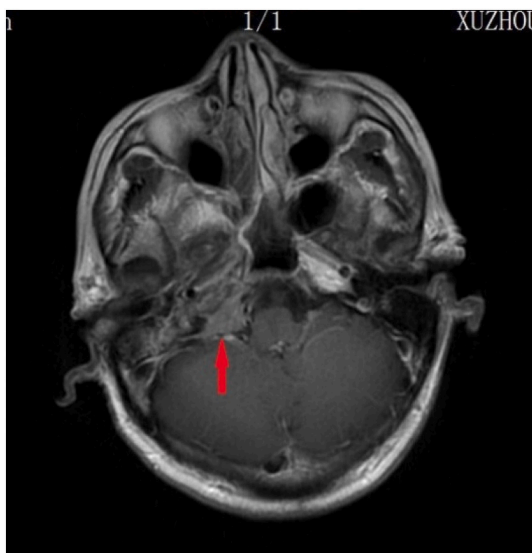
Brain MRI demonstrating an enhanced mass lesion in the right cerebellopontine angle.
